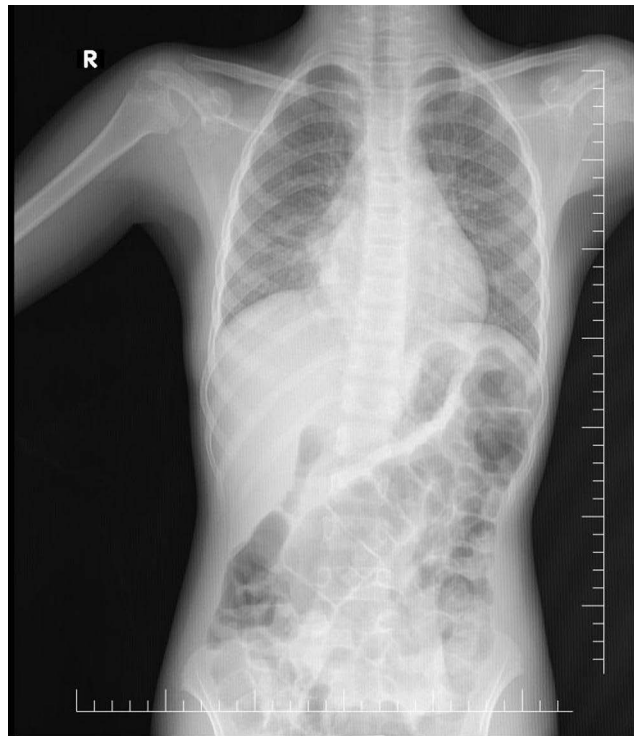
Post-bronchoscopy chest radiograph demonstrating complete resolution of the previously noted right bronchial foreign body, with normalization of lung aeration and mediastinal alignment. No residual radiopaque object, atelectasis, or air-trapping is observed.
